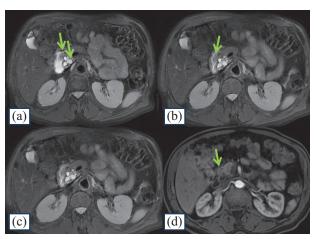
Pancreatic MRI in T2 axial FS WS (a, b, c) and T1 after contrast enhancement WS (d) showed the presence of aberrant pancreatic tissue in the inner wall of the second duodenum (green arrow).
